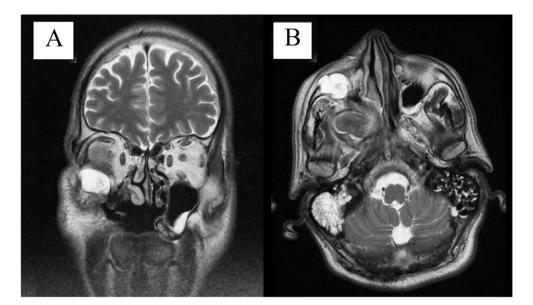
T2 Magnetic resonance imaging (MRI) in January 2014: A: Coronal view showing a round enhanced mass in the inferior orbit. B: Axial view.
